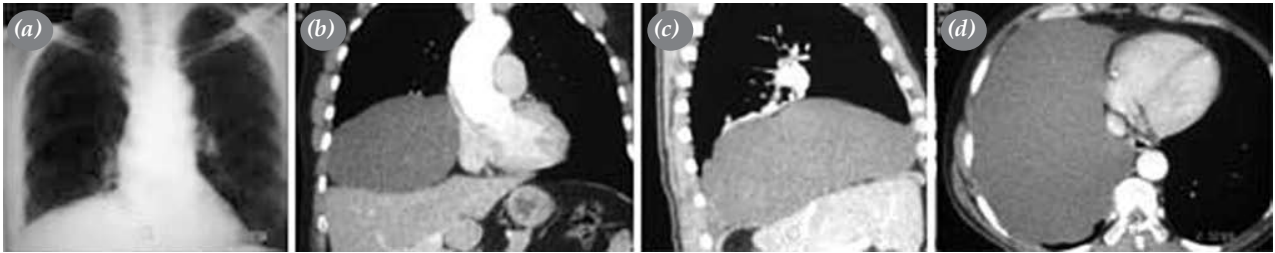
(a) Plain chest X-ray shows right lower lobe atelectasis. Appearance of the cyst on (b) coronal, (c) sagittal, and (d) axial images of multislice computed tomography.
